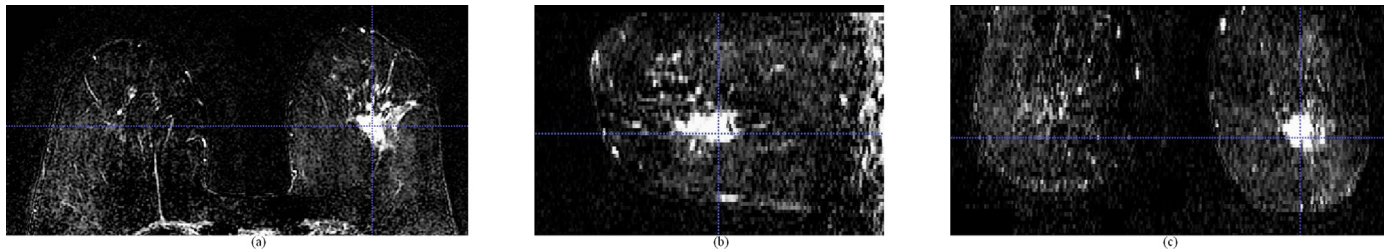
Sample T2-weighted MRI displaying Stage II from the TCGA-BRCA data set, (a) axial view, (b) sagittal view, and (c) coronal view.
